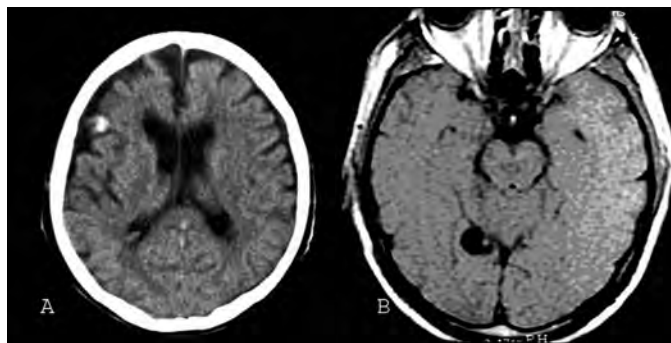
(A) CT scan. Single calcified cysticerci located in right hemisphere. Small hyper dense nodules in CT (<2 mm) were considered as calcified cysticerci because of showing the typical radiological features of calcified cysticerci and considering the high NC prevalence in Mexico. (B) MRI. Single vesicular NC located in the right hemisphere.
